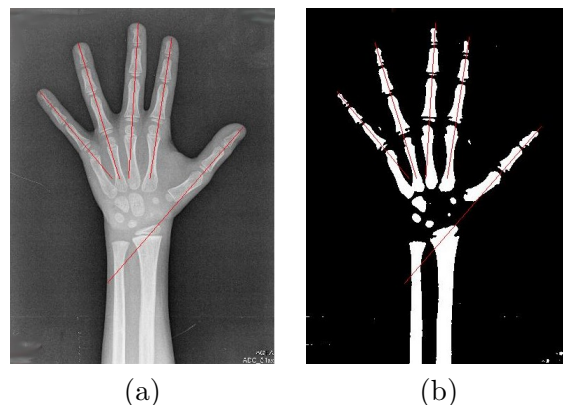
a) Finger axes over the original X-ray; b) Finger axes over the segmented image.
